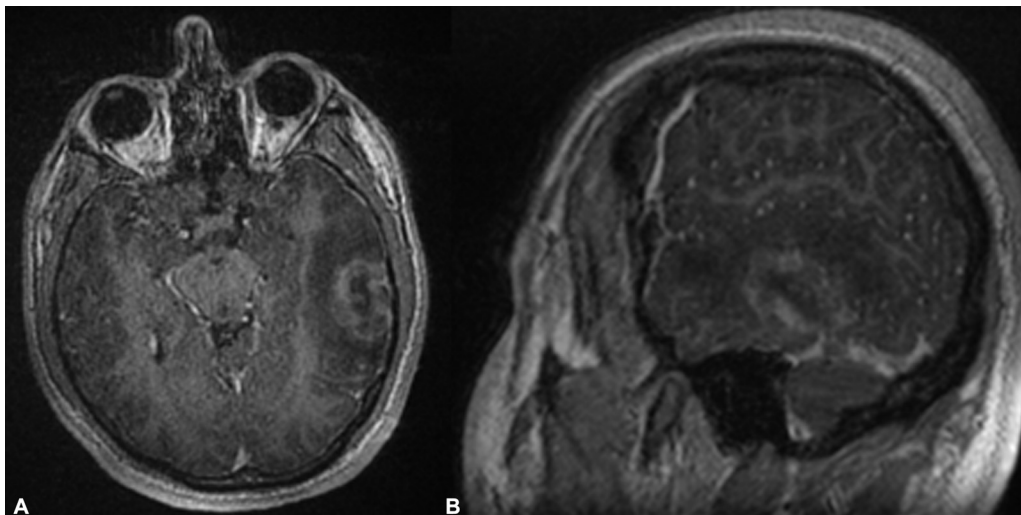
Axial and sagittal T1WI MRI with gadolinium showing heterogeneous enhancement of the lesion.
